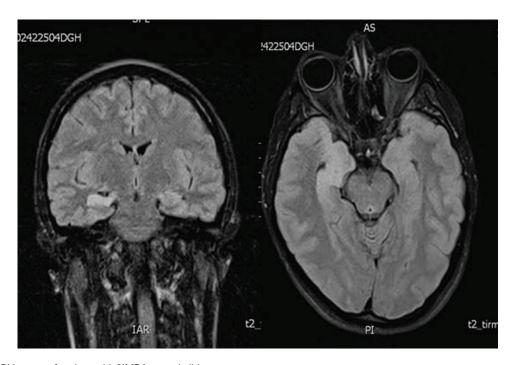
MRI images of patient with NMDA encephalitis.
